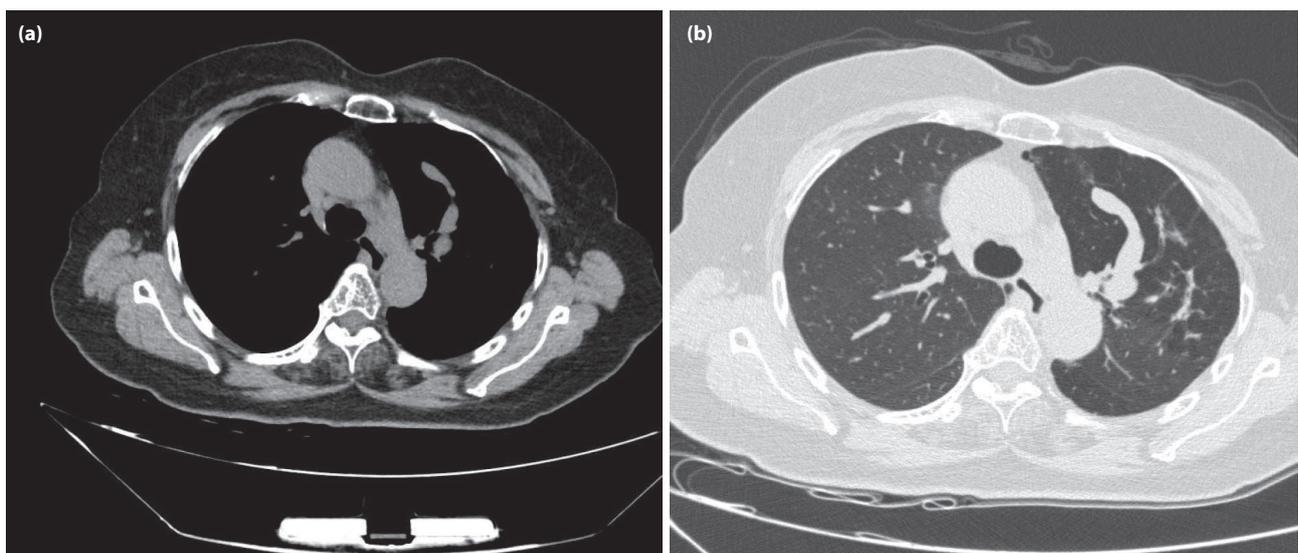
Chest computed tomography (CT) reveals fluid density material located dependently within the left bronchus. The classic feature seen when plugged mucus extends along large branching airways is the finger-in-glove sign.
